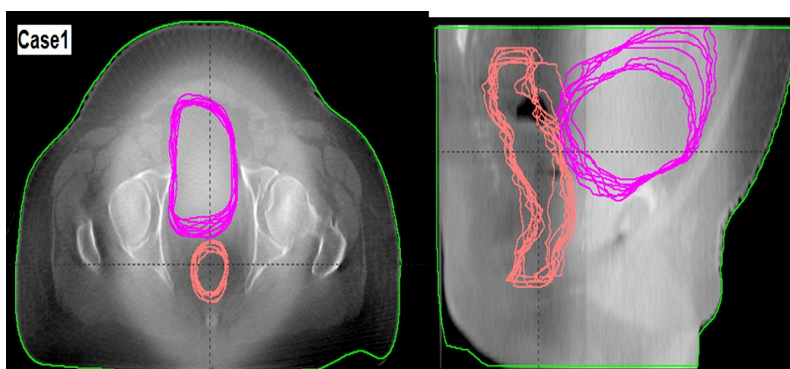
Contours of bladder and rectum drawn in daily cbct images overlaid in single axial and sagittal slice.
